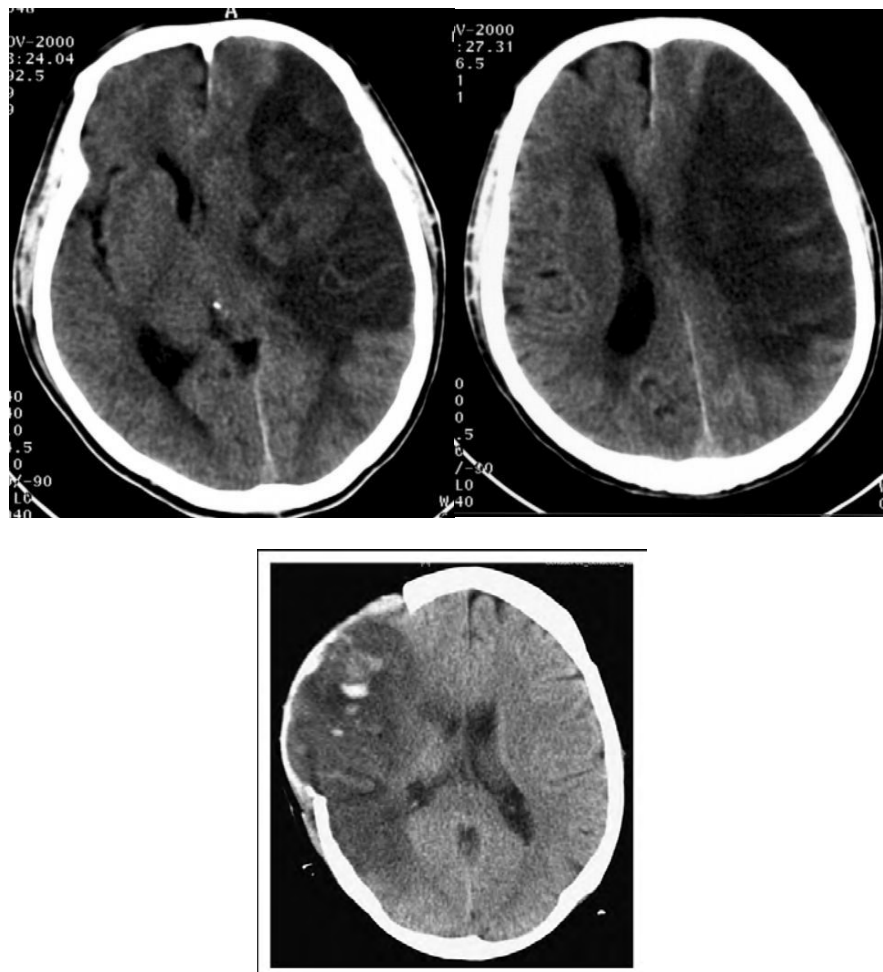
Plain CT scan showing evolving infarcts on left MCA territory with hemorrhagic transformation in the right MCA territory.
